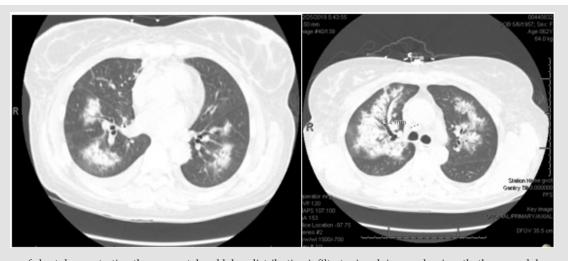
CT scan of chest demonstrating the segmental and lobar distribution infiltrates involving predominantly the upper lobes.
